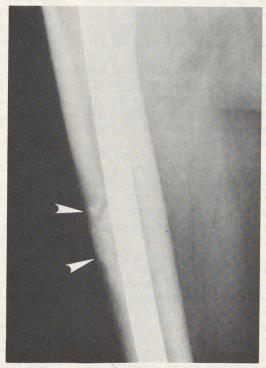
Postoperative AP radiograph of femur of patient described in Figure 3. The lesion has been curretted and the defect filled with methylmethacrylate (arrows). A Kuntcher nail has been inserted down the medullary canal for added stability.
